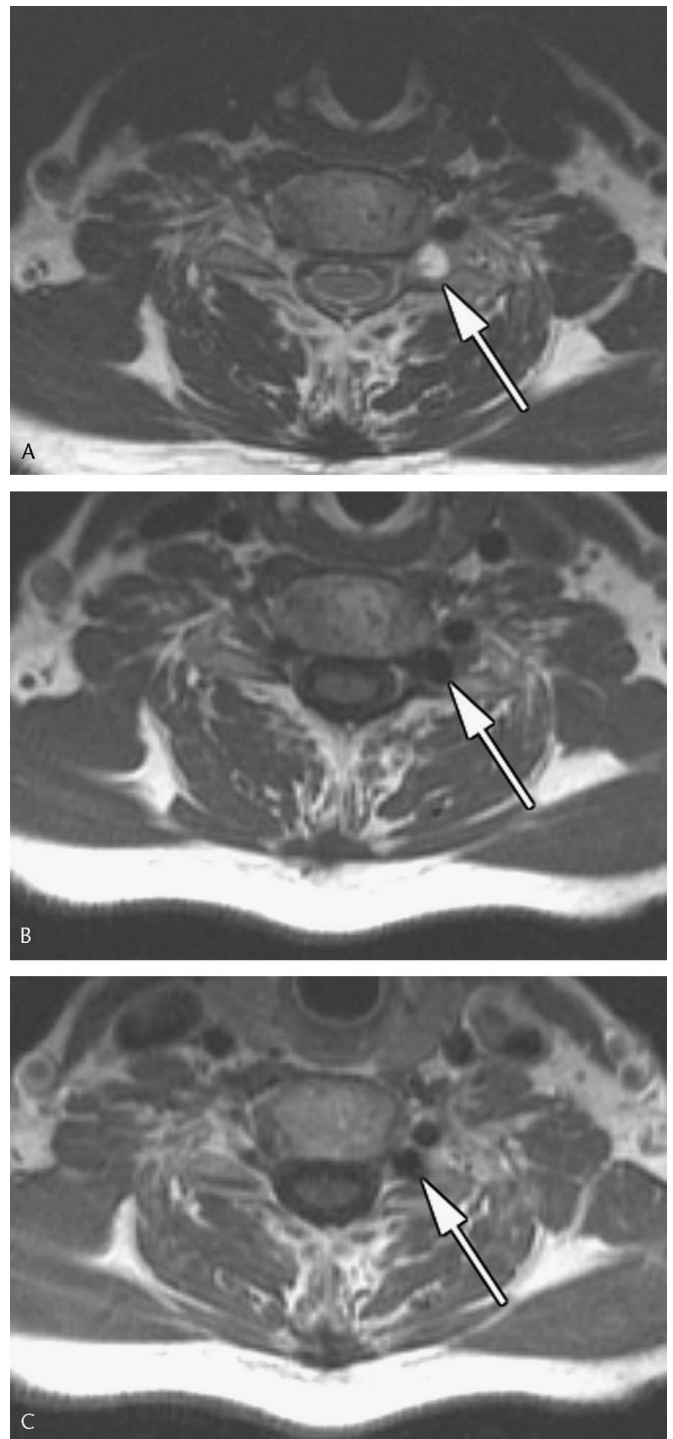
Perineural cyst (indicated by arrows). A, Axial T2-weighted image shows extension of cerebrospinal fluid into the left neural foramina, consistent with perineural cyst. B, Axial precontrast T1-weighted image shows the same. C, Axial postcontrast T1-weighted image demonstrates no enhancement.
